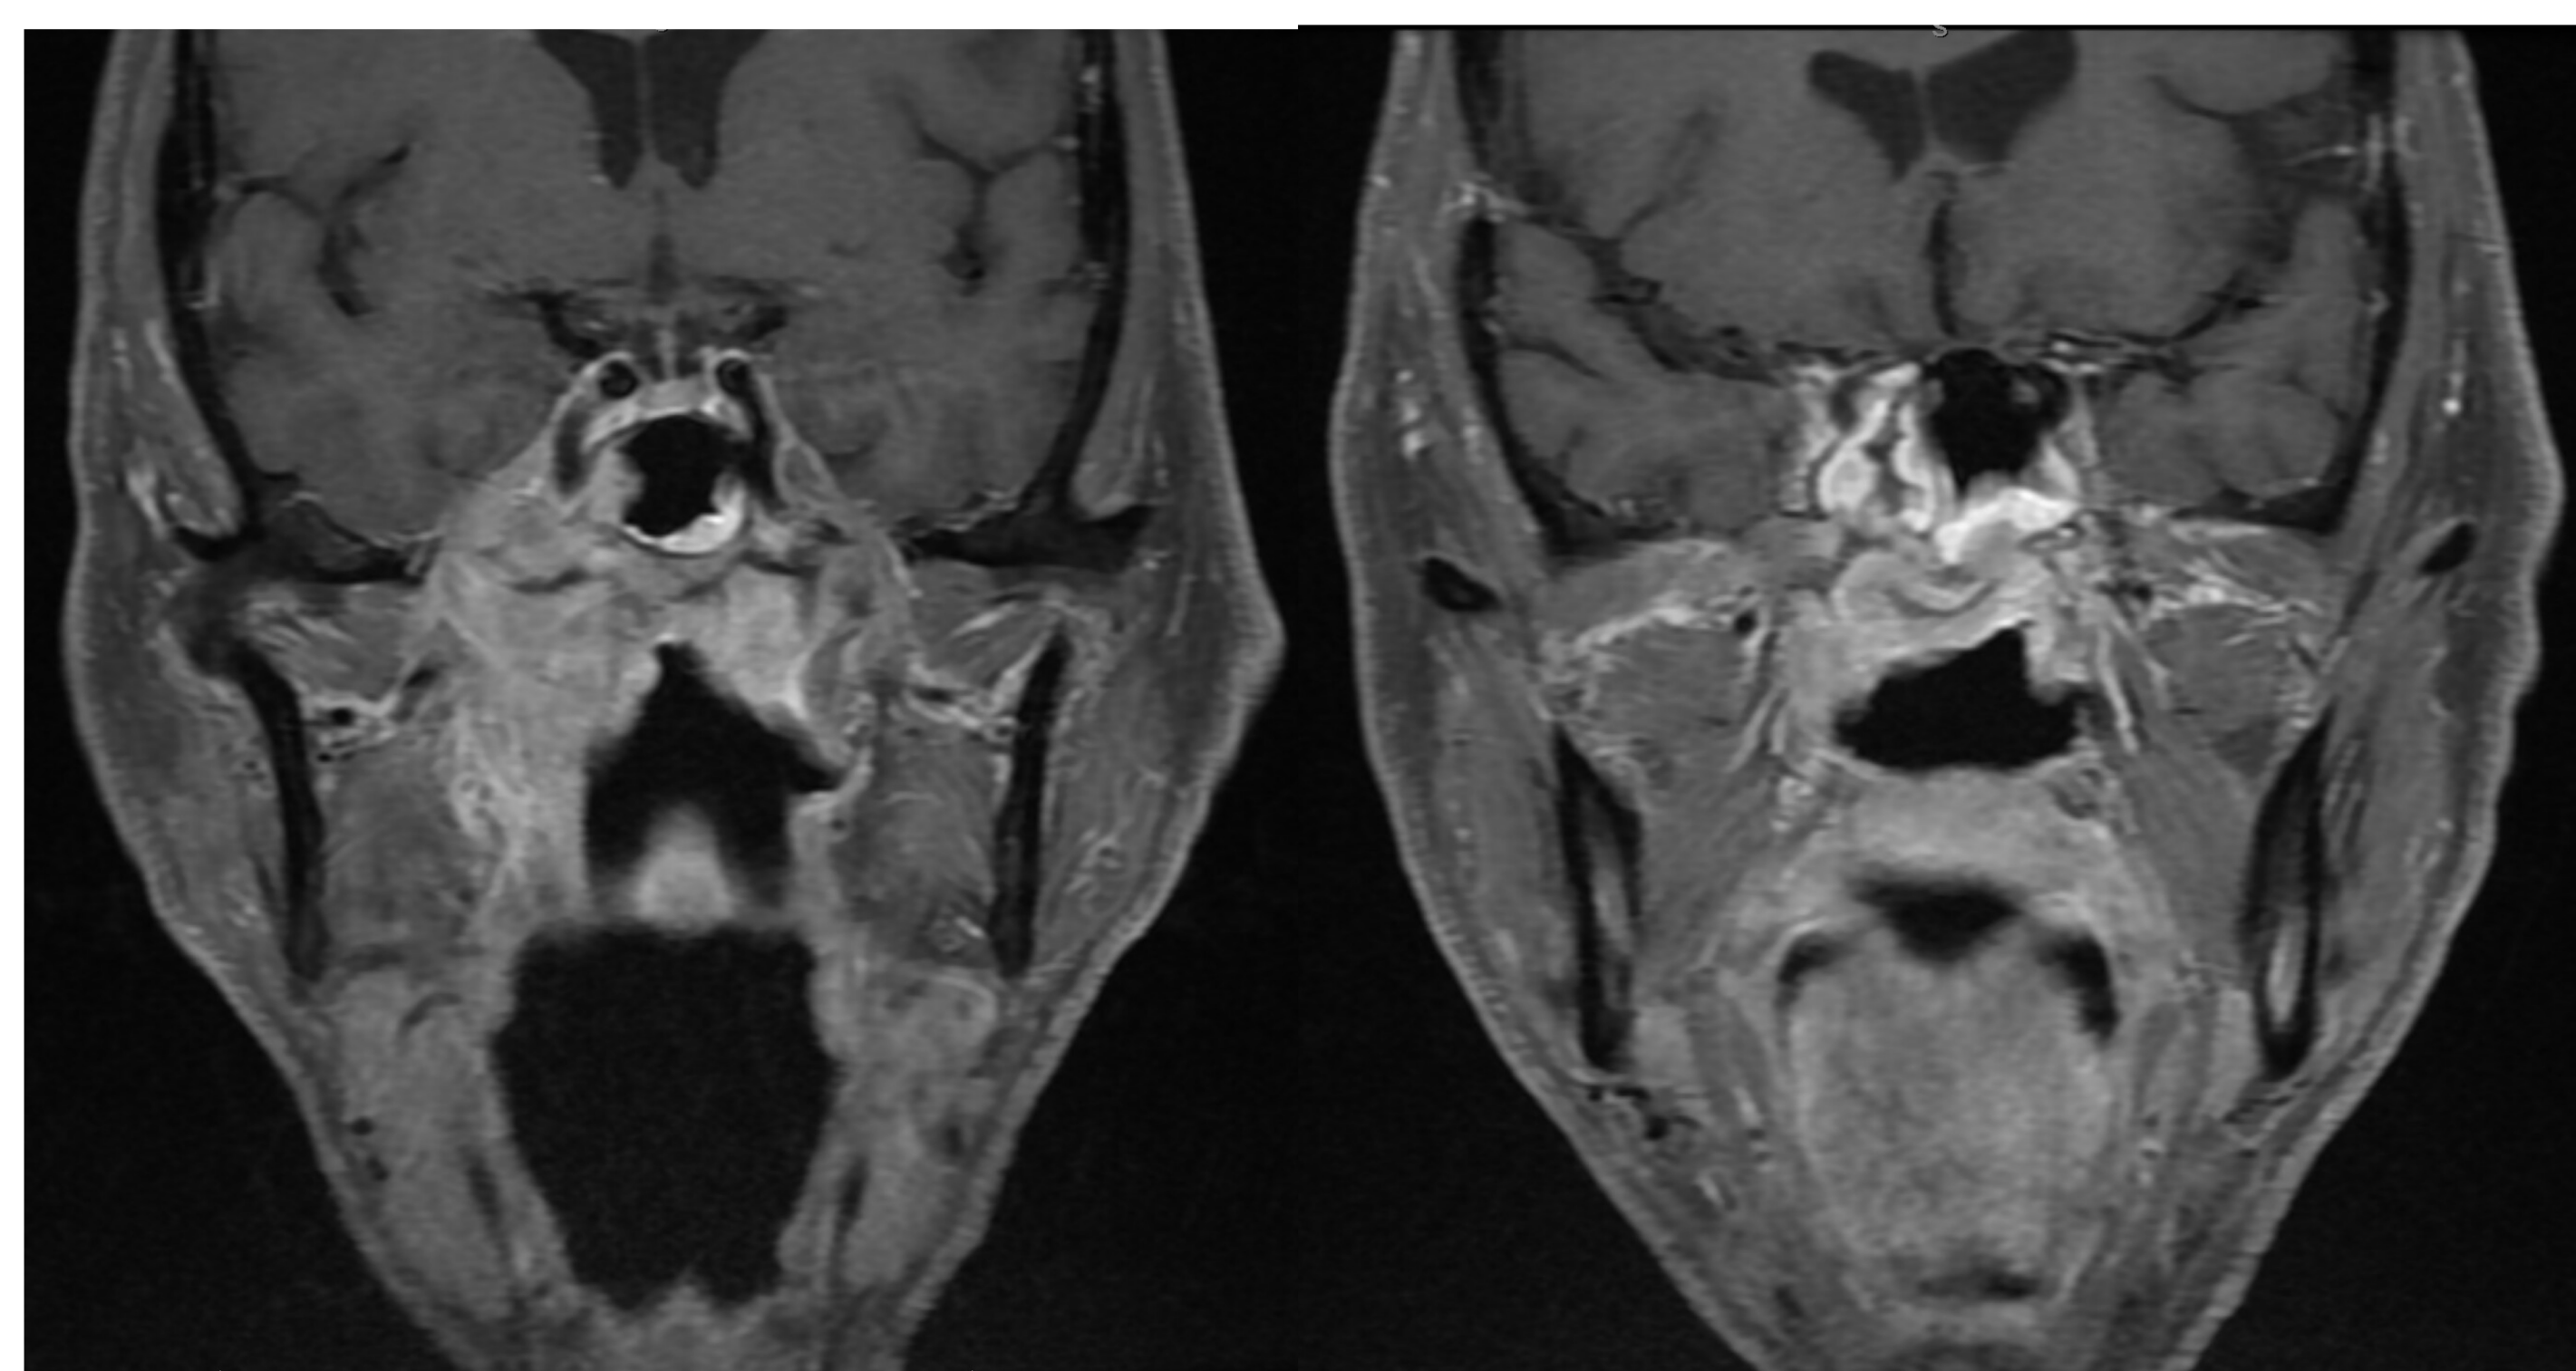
Preoperative MRI demonstrating enhancement of the right temporal lobe and cavernous sinus.
